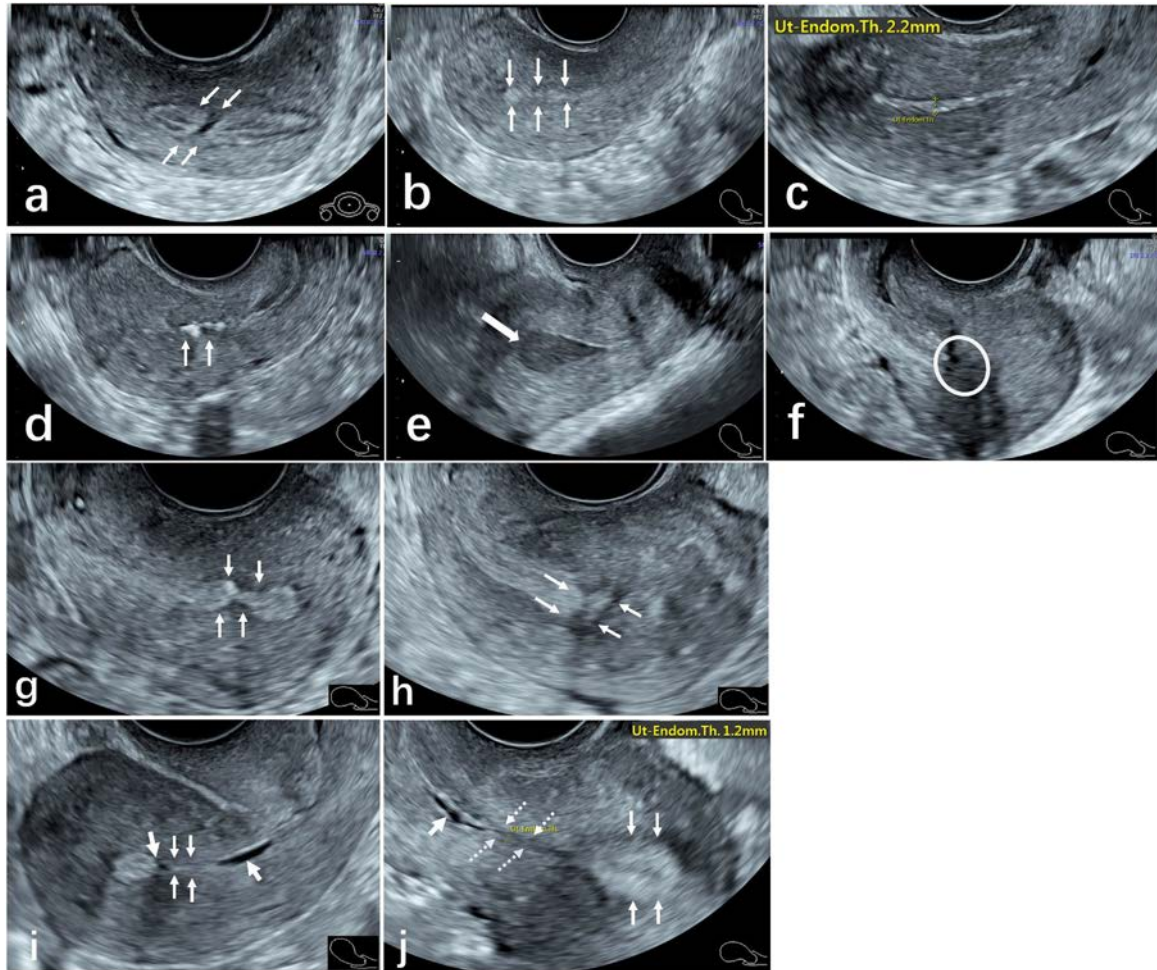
Examples of 2D ultrasonography features associated with intrauterine adhesions. (a) Broken endometrial echo in the transverse plane (arrows). (b) Endometrium with an irregular margin (arrows). (c) Thin endometrium (<3 mm), measured on the longitudinal section of the uterus, from the echogenic interface of the junction of the endometrium and myometrium. (d) Multiple hyperechoic foci in the middle segment of the cavity (arrows). (e) Fluid distending the upper uterine cavity (arrow). (f) Loss of the endometrial echo (circle). (g) Constriction of the endometrial echo in the upper uterine cavity (arrows). (h) A broken or interrupted endometrial echo in the upper part of the uterine cavity (arrows). (i) Two features indicative of intrauterine adhesions, i.e. a small amount of fluid in the upper and lower halves of the endometrial cavity (thick arrows), and irregular endometrium (thin arrows). (j) Multiple features suggestive of intrauterine adhesions: the upper third of the endometrial echo exhibits a fuzzy margin (thin arrows); the middle third of the echo is thin and poorly defined (dotted arrows); and the lower third contains a small amount of intracavity fluid (thick arrow).
